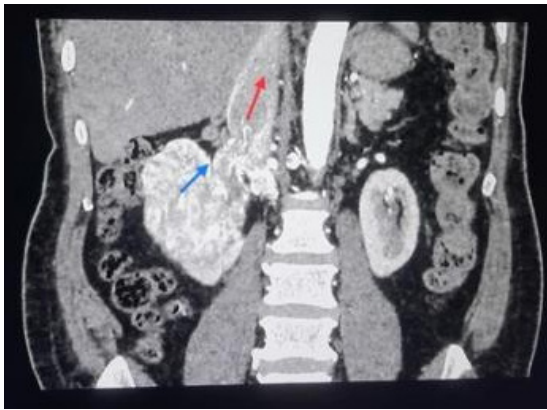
Contrast enhanced abdominal computed tomography scan showing the renal cell carcinoma in the right moiety of the horseshoe kidney (blue arrow), with Inferior vena cava tumour thrombus (red arrow)
